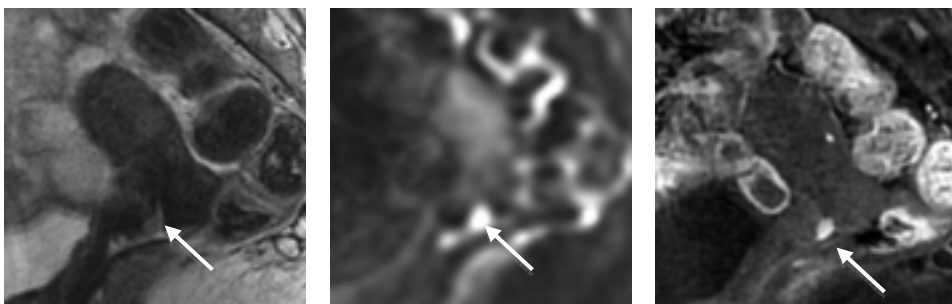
Stage Ib1 cervical cancer: Slight high intense small lesion is visible but not clear on T2-weighted image (left). Very high intense nodule (Type a) is observed on DWI (middle). Intense CE area (Type A) in the early phase of 3D-DCE-MRI (right).
